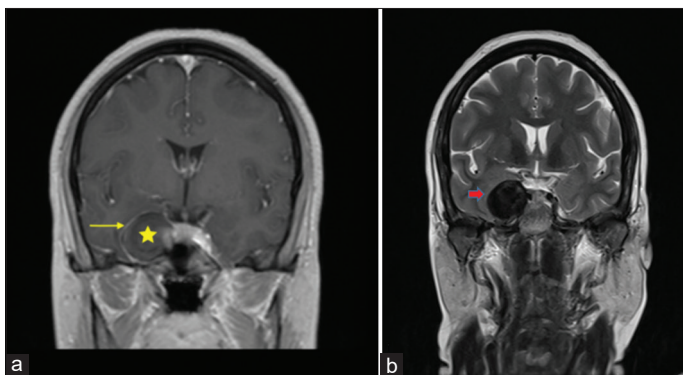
(a) Post-contrast magnetic resonance angiography of a giant internal carotid artery (ICA) thrombus - The image reveals a giant saccular aneurysmal dilatation in the intra-cavernous segment of the right ICA, with a central non-enhancing thrombus (yellow star) surrounded by a rim of contrast-enhancing patent lumen (yellow arrow); (b) T2-weighted coronal magnetic resonance imaging of a giant ICA thrombus
